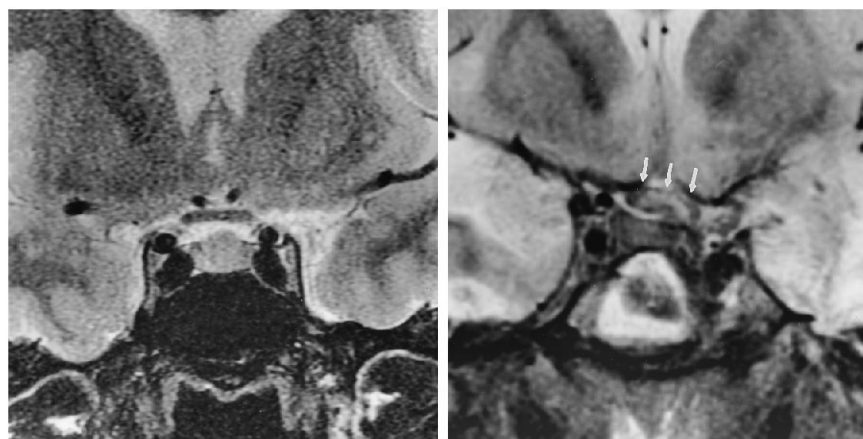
Healthy volunteer and chiasmic contusion. A, T2-weighted (3100/92 effective) coronal image showing the chiasm of a healthy subject. This image was obtained with a  $512 \times 256$  matrix. Note the signal-to-noise loss compared with B. B, T2-weighted (3100/92 effective) coronal image displays a swollen chiasm with internal ovoid high signal thought to represent contusion (*arrows*). Bilateral temporal and inferior frontal contusions are also present.
